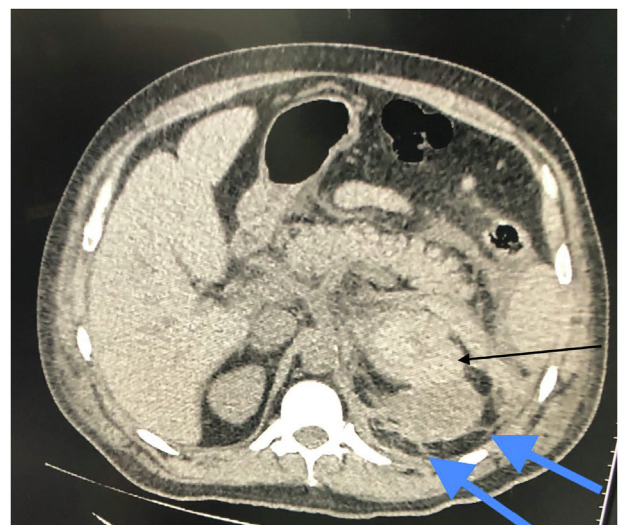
Pre-operative CT. Black arrow showing a left suprarenal hyperdense mass. Blue arrows showing retroperitoneal haematoma with perinephric fatty stranding.
